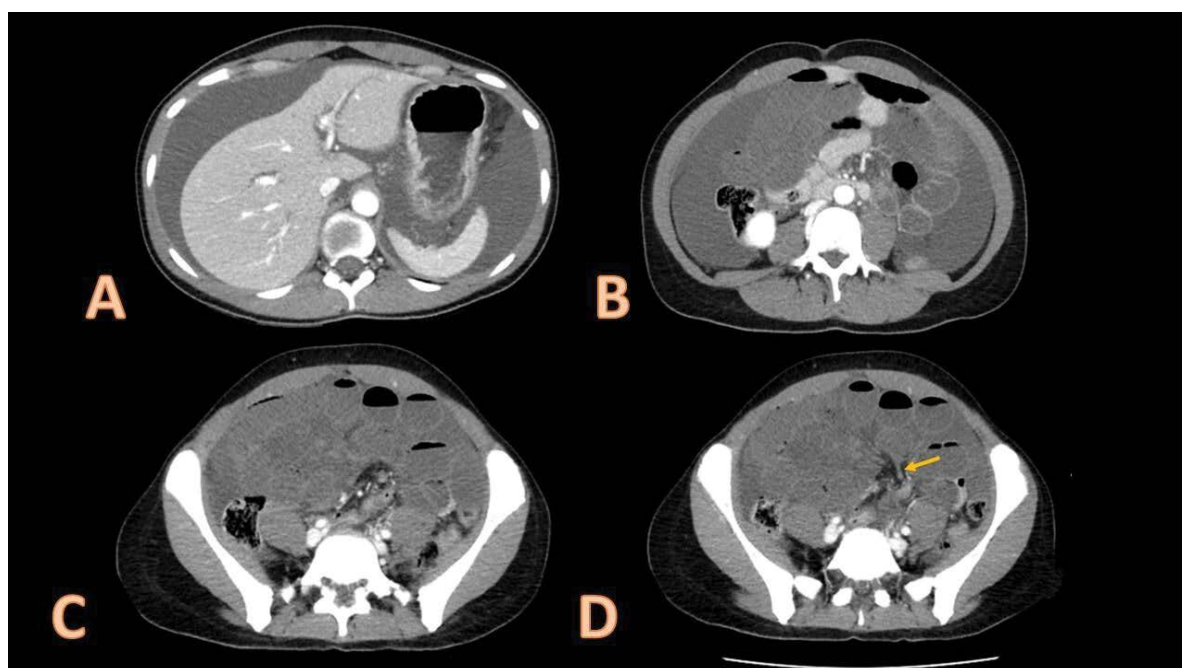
Abdominal CT scan with contrast medium administration (axial plane). Small bowel loop involvement (distal jejunum and proximal ileum) with submucosal edema and absence of enhancement after contrast. In addition, a change in caliber in the loop of the ileum located in the hypogastrium is identified (arrow). A significant increase in free intraperitoneal fluid with marked ascites is also observed. No signs of pneumoperitoneum or defined collections were detected.
